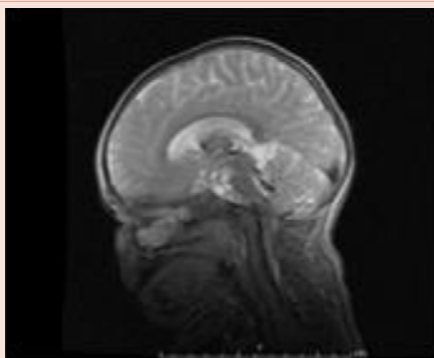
MRI of the brain and neck showing critical narrowing of the foramen magnum with severe mass effect on the medulla.
